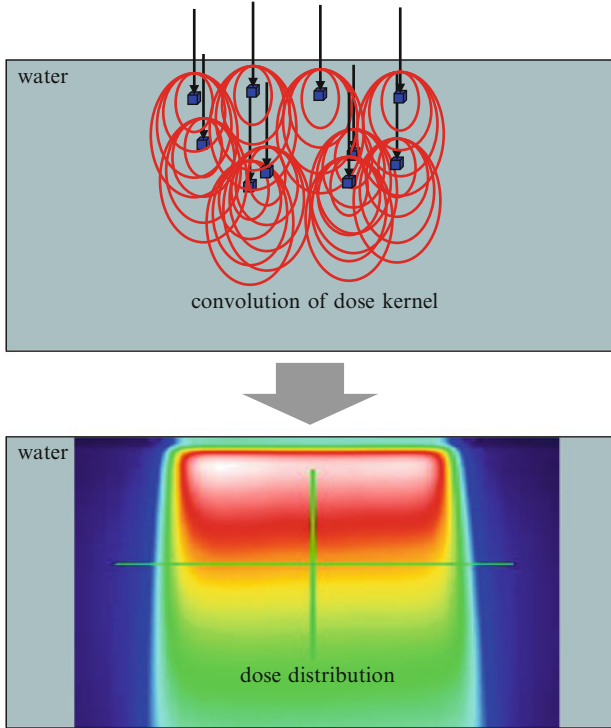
An example of the dose distribution of X-rays used in radiation therapy
